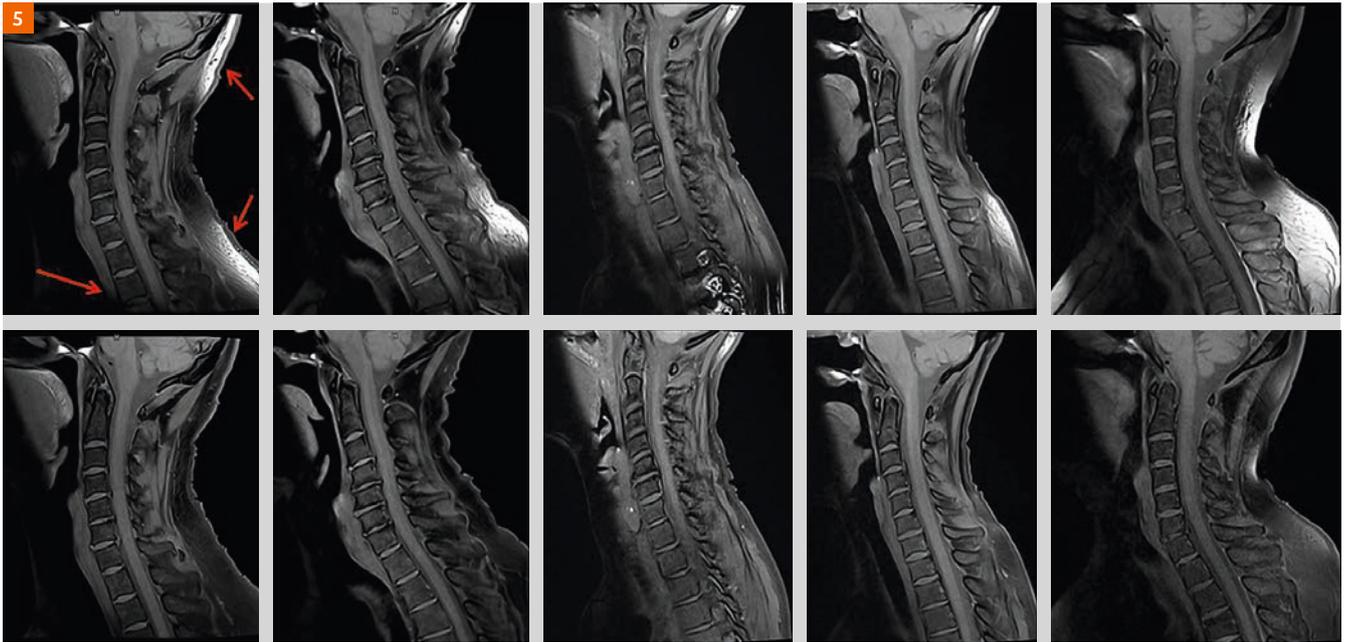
T1-weighted TSE images with fat saturation in five different volunteers. Using CoilShim (lower row) improved the fat saturation not only within the vertebrae but also in the posterior areas. The contrast between vertebrae and disk is also improved.
